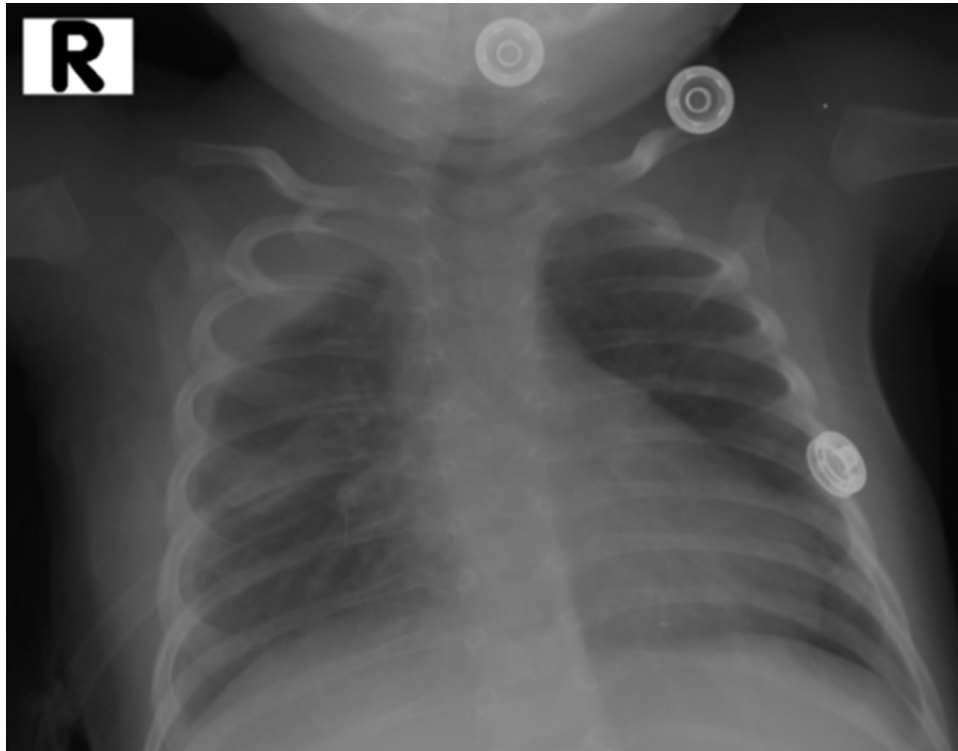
AP Chest X-ray showed improvement after chest tube insertion. The right lung expanded, trachea, and mediastinal are in a normal position after empyema drainage.
